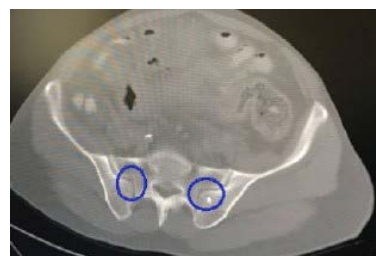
Axial computed tomography section image of the bilateral iliosacral complex at the S2 vertebra level in a 60-year-old man patient. A protrusion and matching cavity is observed on the iliac surface.
